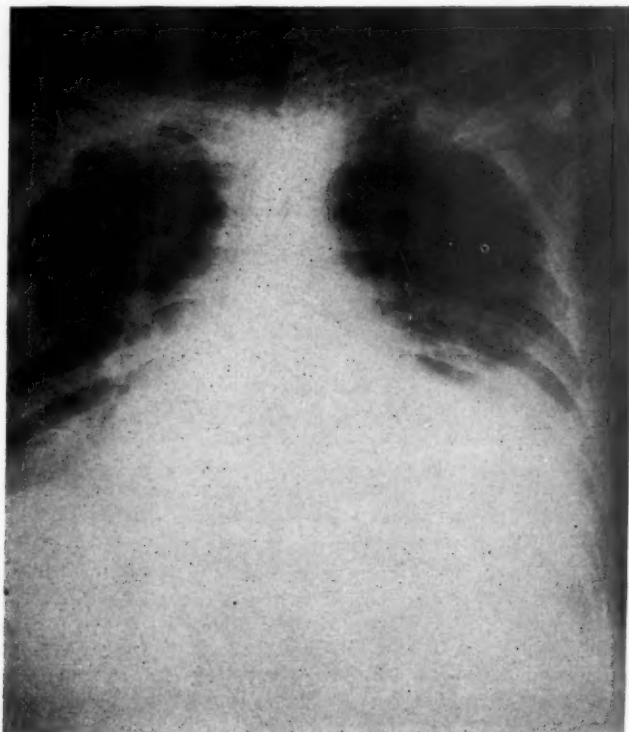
Roentgenogram of chest (mobile unit), showing markedly enlarged heart and densities in both lung bases.
